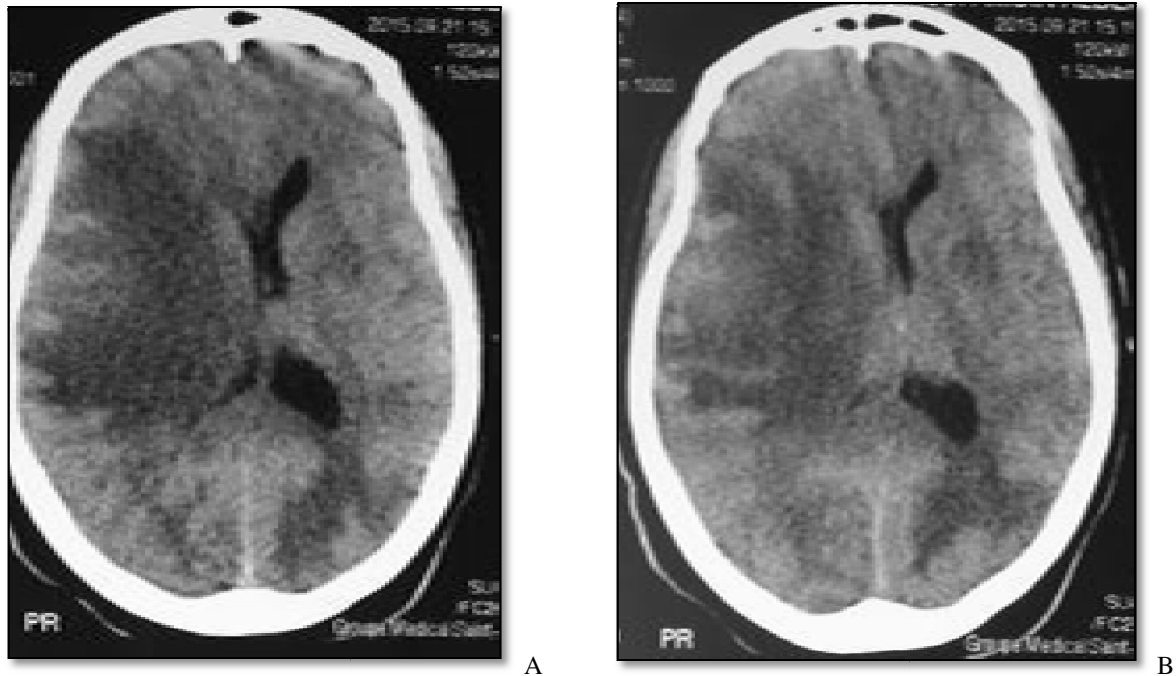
Brain CT in axial sections. A (without IV) and B (after IV): convulsive seizures in a 47- year-old woman with fever and a notion of HIV /AIDS. The brain CT shows a large vasogenic edema taking discreet contrast (pre-suppurative encephalitis)
